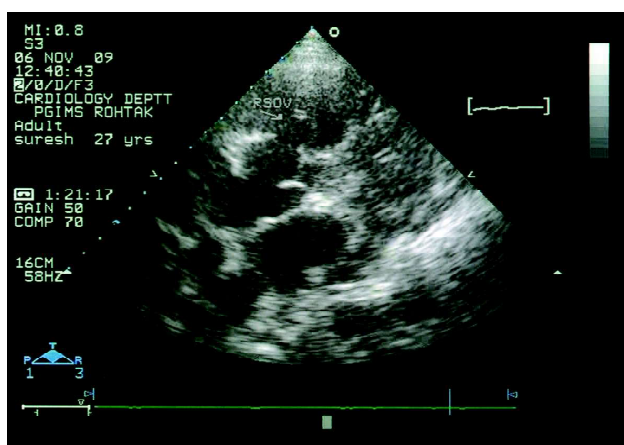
Echocardiogram showing ruptured sinus of Valsalva.
